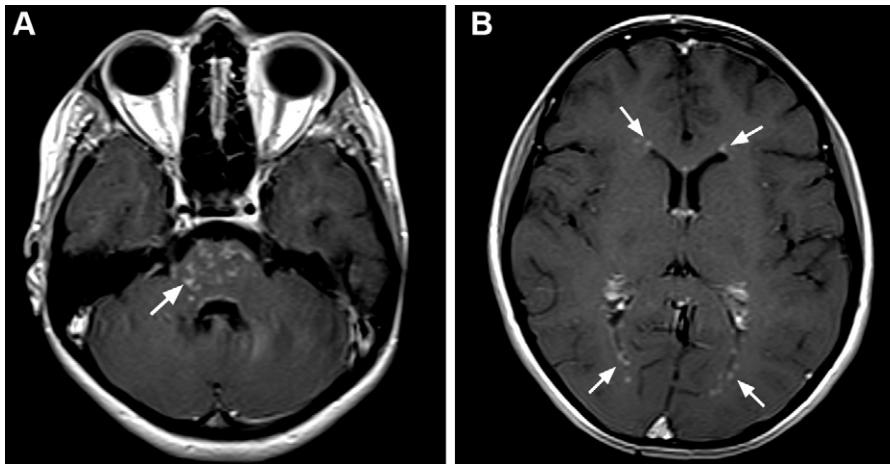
Neurosarcoidosis in a 16-year-old adolescent girl. Axial postcontrast T1-weighted MR images show multiple punctate areas of contrast enhancement suggesting perivascular involvement in the pons and the bilateral periventricular regions (arrows).
